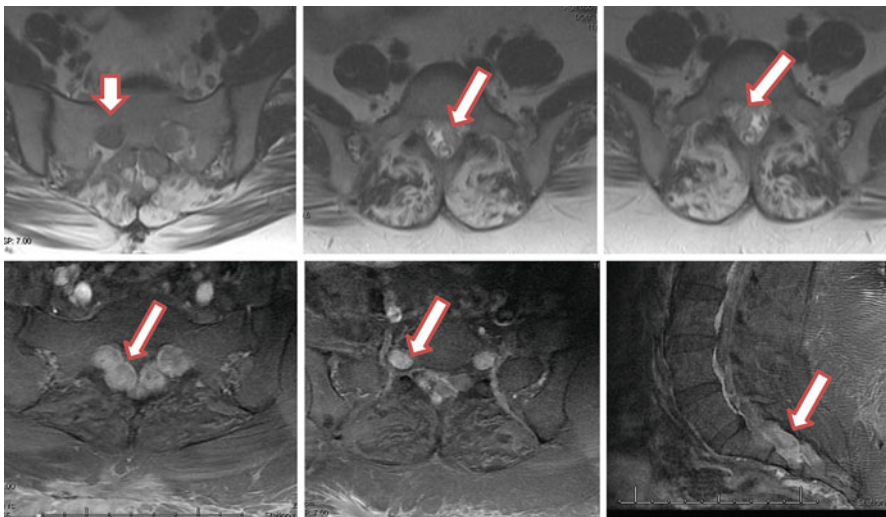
MRI Lumbar Spine images for case example 6. *Top row:* T2-weighted images showing thickened nerve roots (*arrows*). *Bottom row:* subsequent gad-enhanced MRI Lumbar Spine showing avidly enhancing nerves indicated by *arrows*
